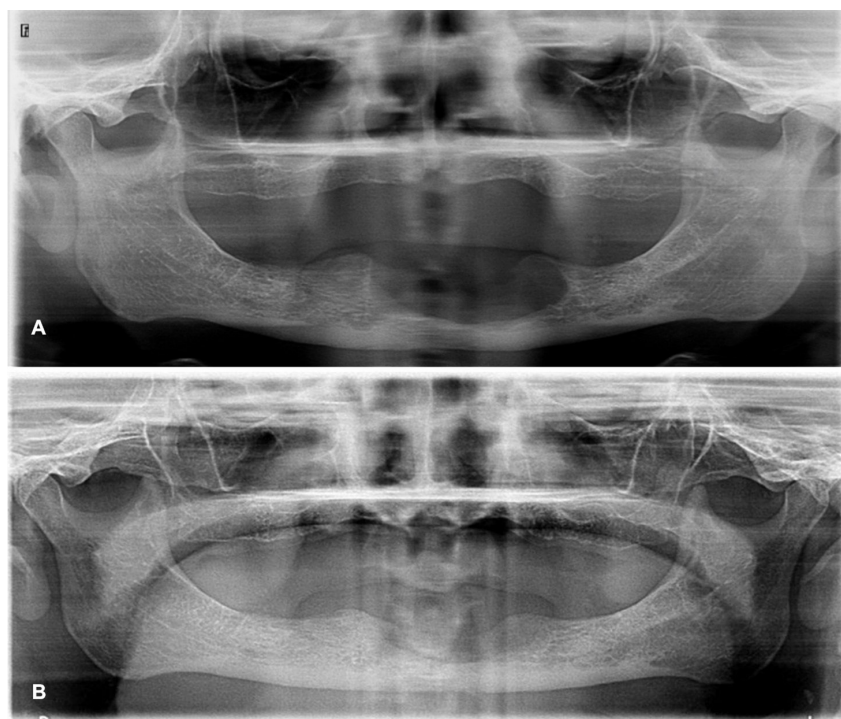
Panoramic radiograph. Osseous repair after two months (A) and six months (B) of lesion removal.
